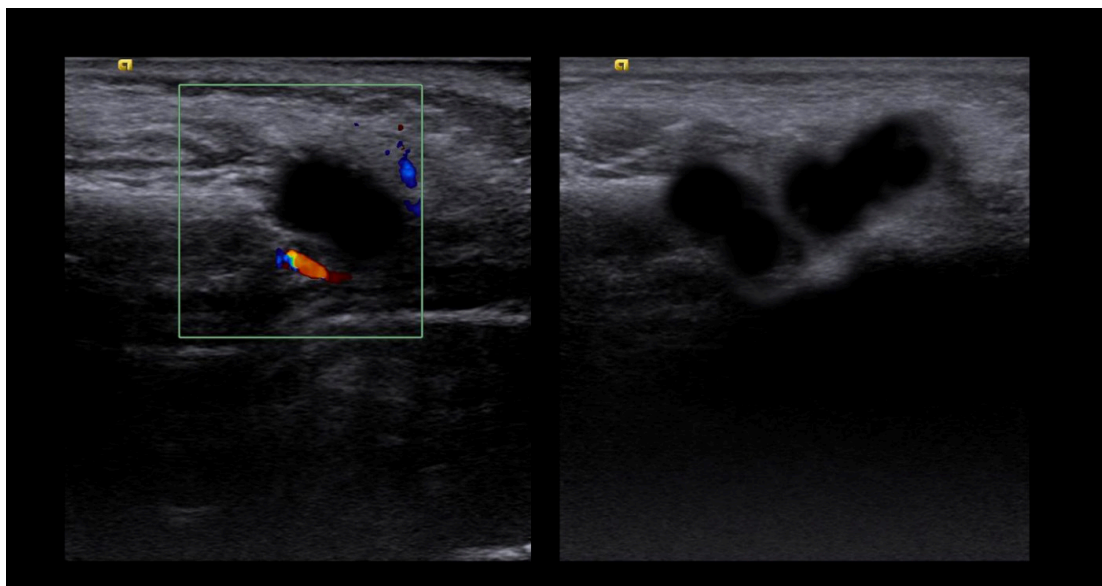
USG showed a pus filled localized swelling in the soft tissue with deep tissue extension. The lesion had a hypoechoic echo pattern without pronounced borders and without increased vascularity in Color Doppler examination.
